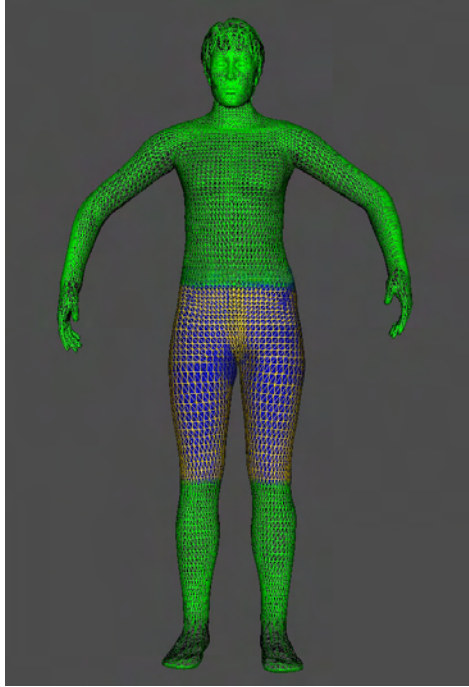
Manual registration: the body scan model and the MRI skin model are perfectly aligned.
